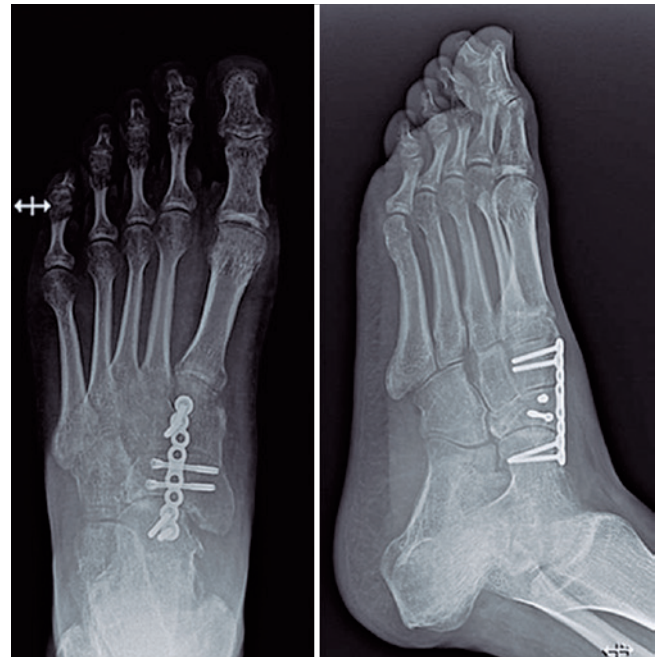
Postoperative radiographs with navicular fracture reduction and restoration of the talonavicular and naviculocuneiform joint congruence and medial column length.
